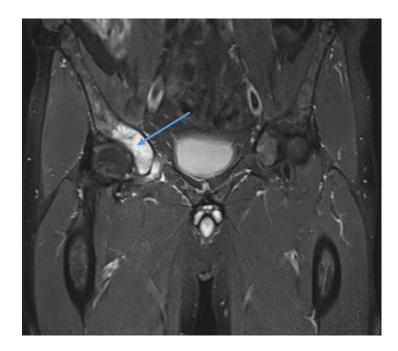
MRI of chondrosarcoma in the pelvic bone (T1 weighted, frontal view).
